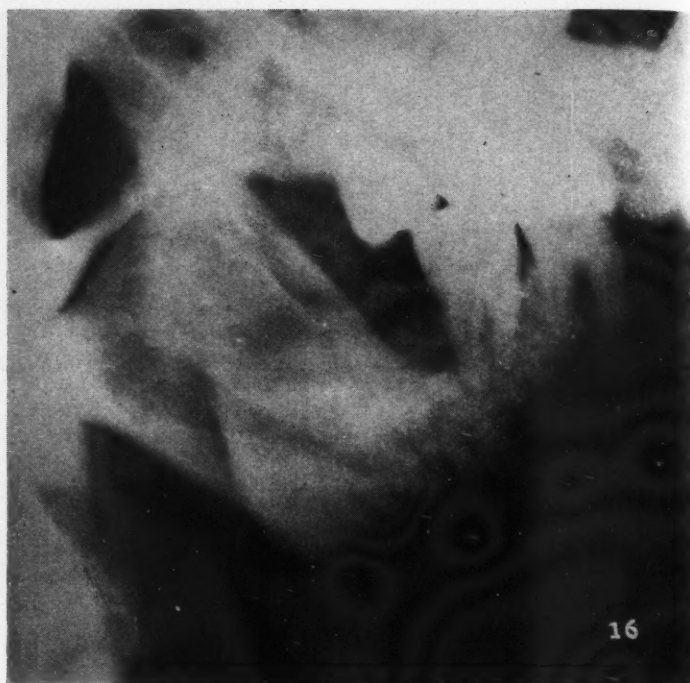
(Case 3)—August 10, 1936. Note complete regeneration of the ramus in eight months' time following permanent drainage of cyst. The time element is recorded by the roentgenograms.
